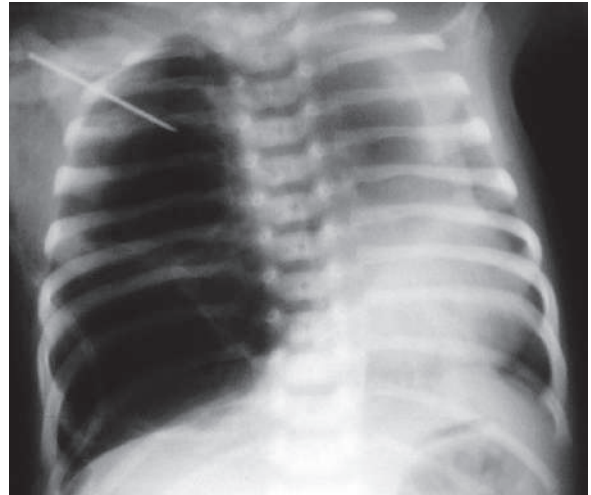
Posteroanterior chest radiograph of a child with right tension pneumothorax shows mediastinal shift toward the left side
